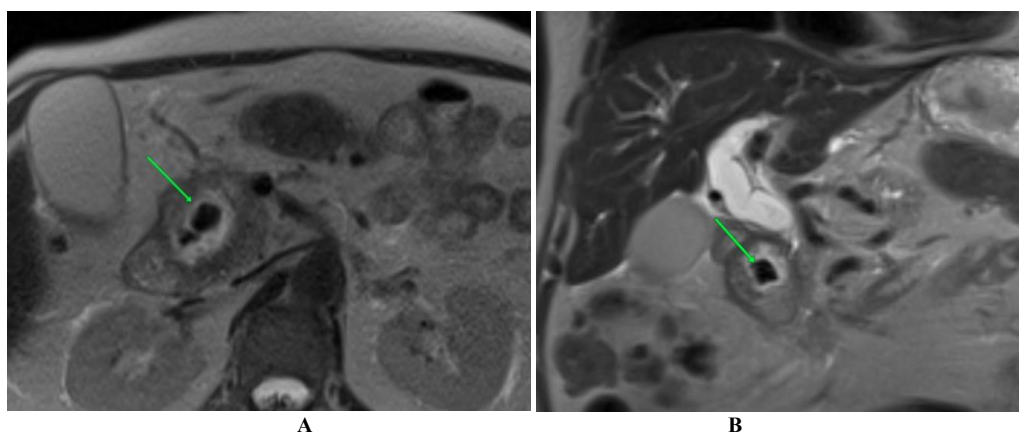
Axial (A) and coronal (B) T2-weighted MRI — Case 1: A 4 cm periapillary duodenal diverticulum (green arrow) causing extrinsic compression of the distal CBD, with upstream biliary dilation to 17 mm. Lemmel syndrome complicated by acute cholangitis.
